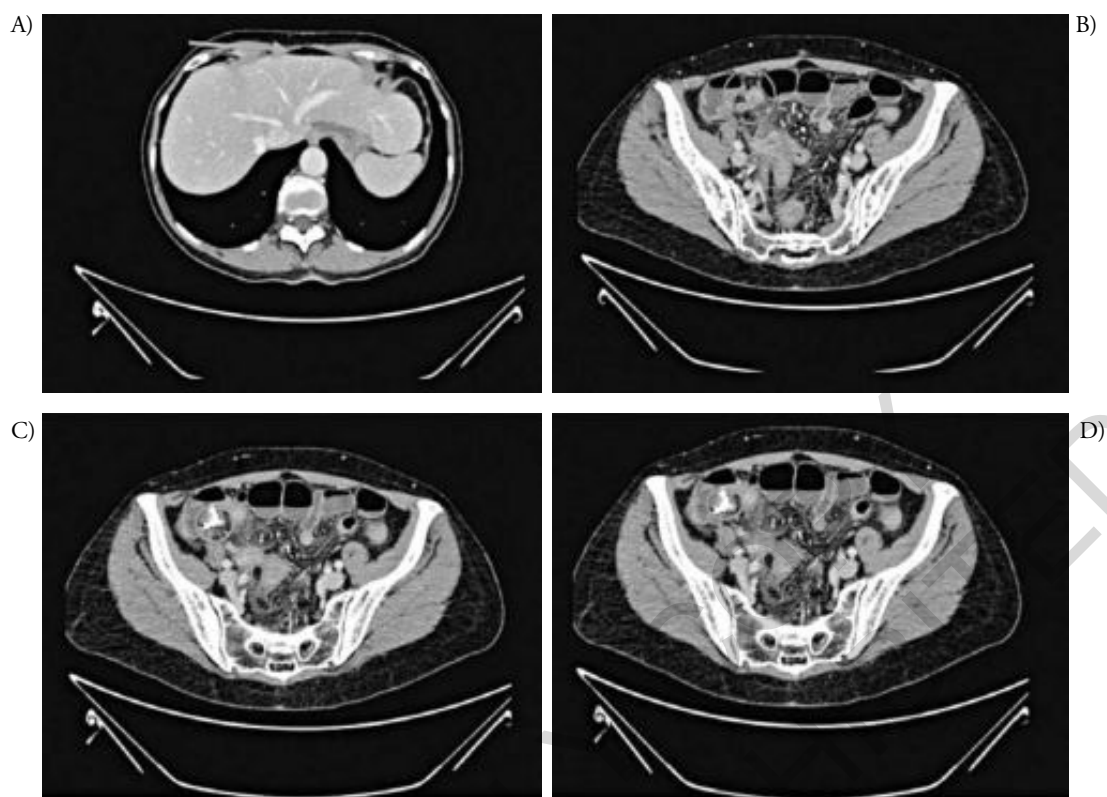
A) CT-scan image showing signs of pneumoperitoneum (red arrow); B) Acute inflammation with edema of the appendicular walls (red circle), due to the closure of its orifice by the OTSC; C-D) OTCS clip closed to the appendicular orifice (red circles), with signs of appendicitis.
